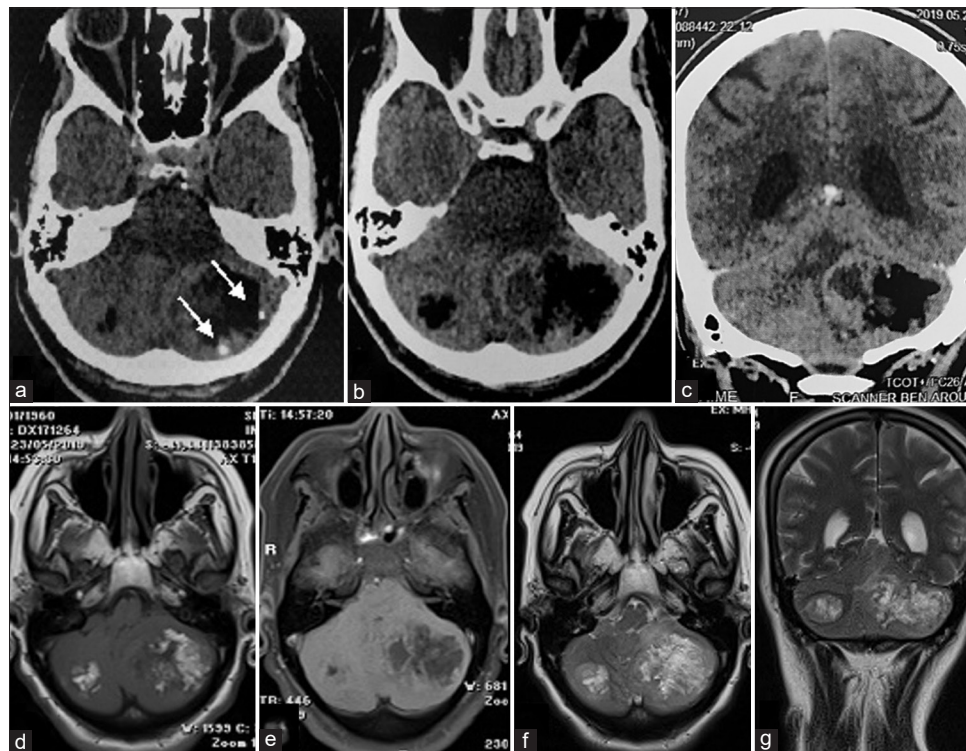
(a and b) Computed tomography scan on axial and (c) coronal sections showing two cerebellar bilateral lesions having the same appearance but the one in the left hemisphere is much larger. The tumor presents an irregular hypodense center which corresponds to a fat component and a peripheral solid isodense part, containing small calcifications (arrows). (d) The fat component is hyperintense on magnetic resonance images T1-weighted images, (e) gets inverted in fat-suppressed images, and (f and g) is hyperintense on T2-weighted images.
